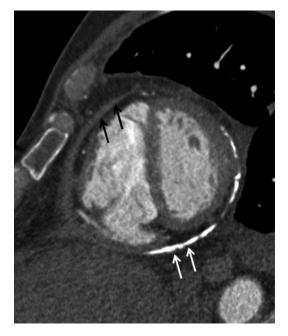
Pericardial thickening (*black arrows*) and calcification (*white arrows*) as demonstrated by CT
